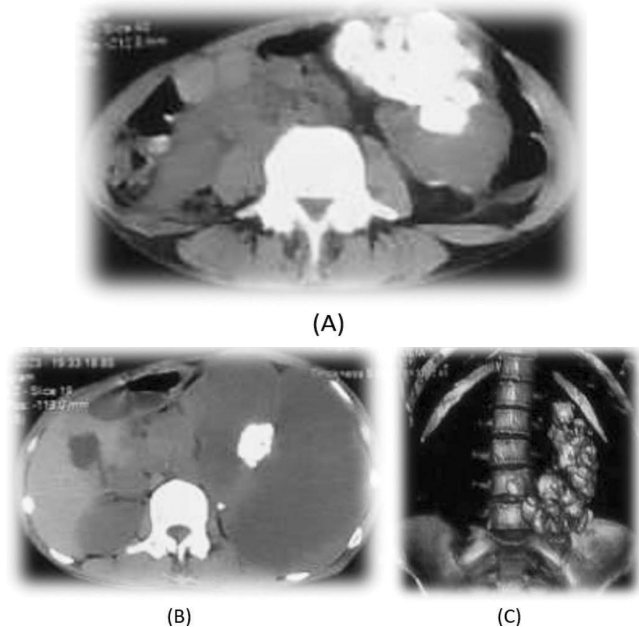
(A-C) Non-contrast enhanced CT scan of the KUB of the patient showing the presence of the staghorn calculus of the left kidney.
